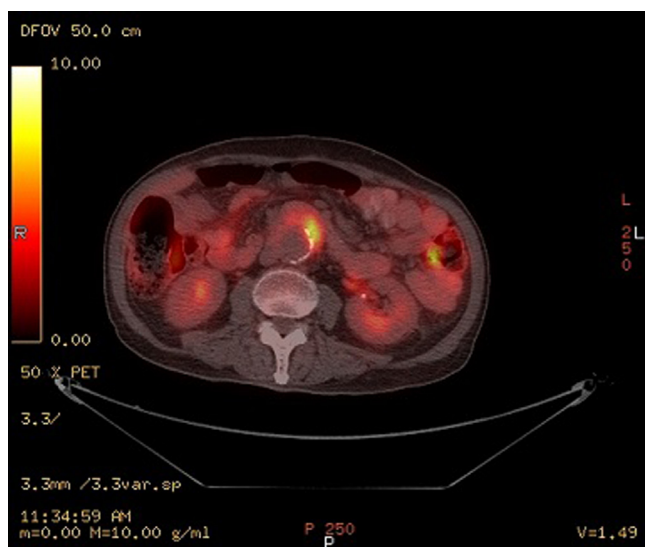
CT PET showing intense tracer uptake in wall of aorta.
